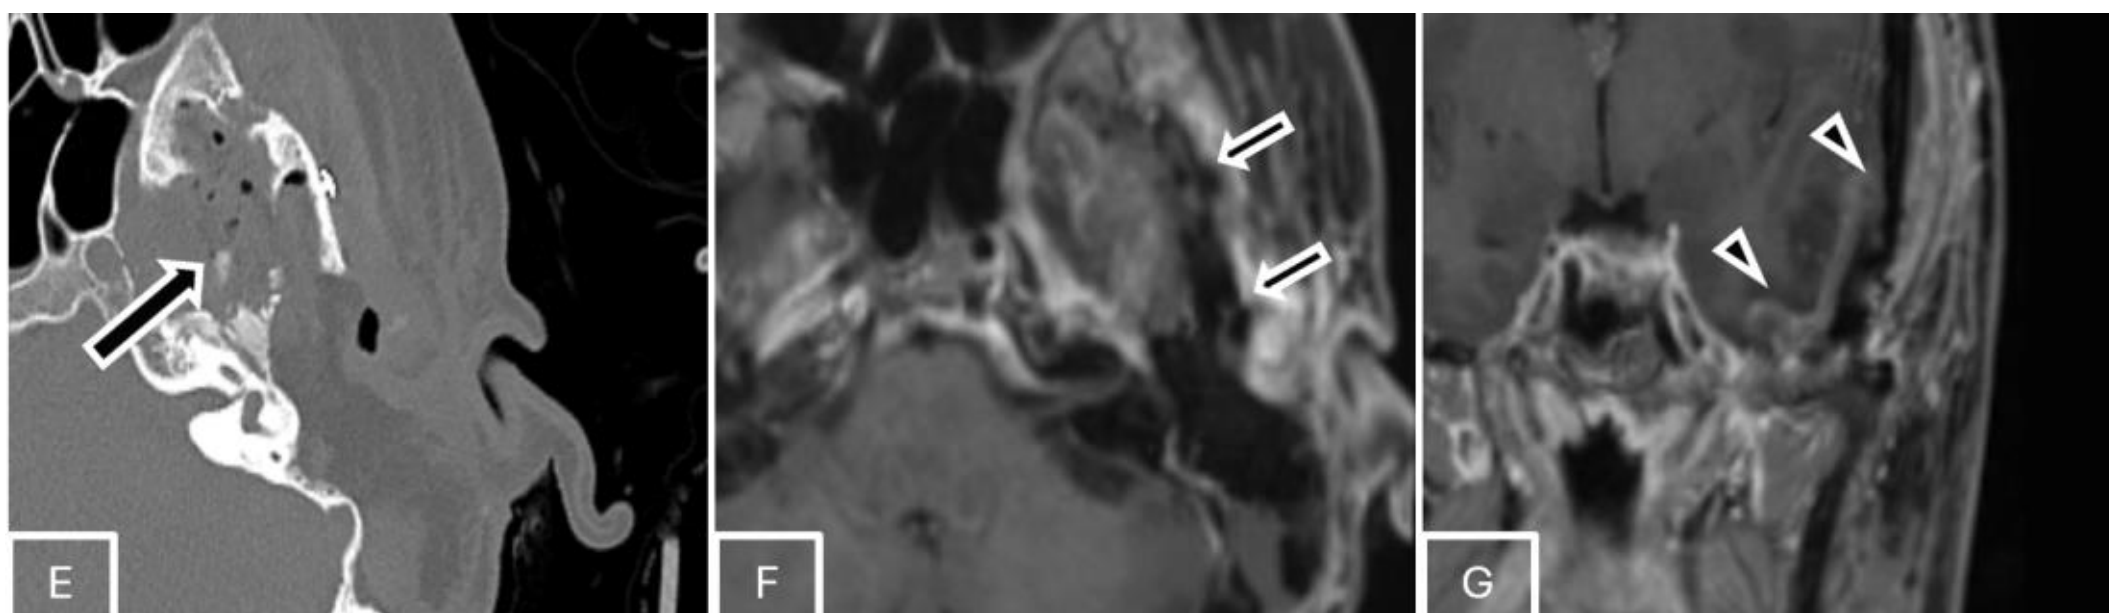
CT and MRI Confirming Successful Resection
